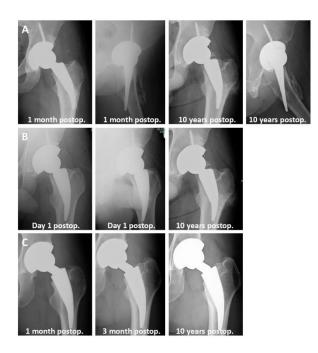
Radiographs of complication cases.
